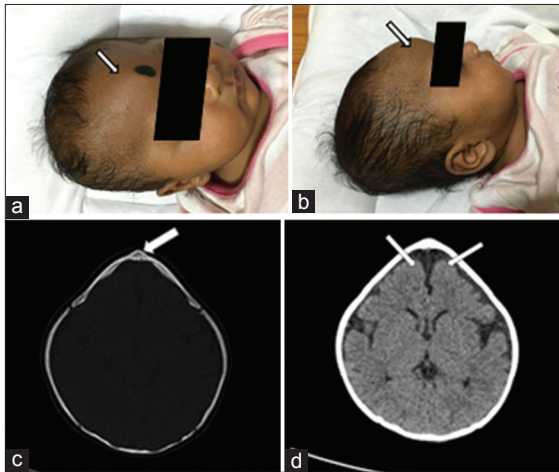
(a and b) Photographs of the baby showing midline frontal ridge (arrows). Multidetector computed tomography showing (c) complete closure of metopic suture (arrow) and (d) frontal lobe minimal atrophy
